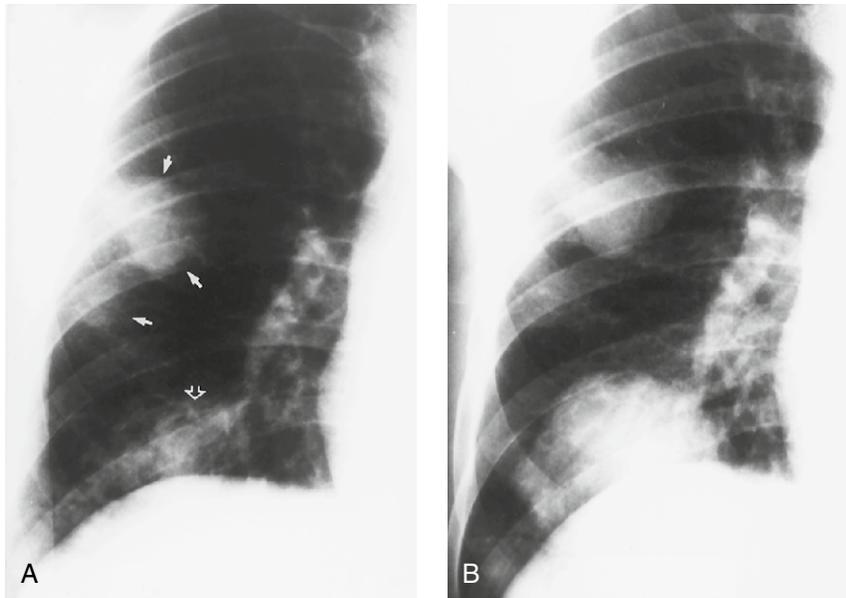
Cryptococcosis. (A) PA chest radiograph coned to the right lower lung demonstrates a mass with adjacent airspace opacity (*arrows*) in the lateral aspect of the lung as well as a subtle, rounded focus airspace disease (*open arrow*) just above the diaphragm. (B) Coned PA chest radiograph taken 18 months later reveals resolution of the airspace disease adjacent to the original mass as well as the evolution of a second mass from the focus of airspace disease above the diaphragm.
